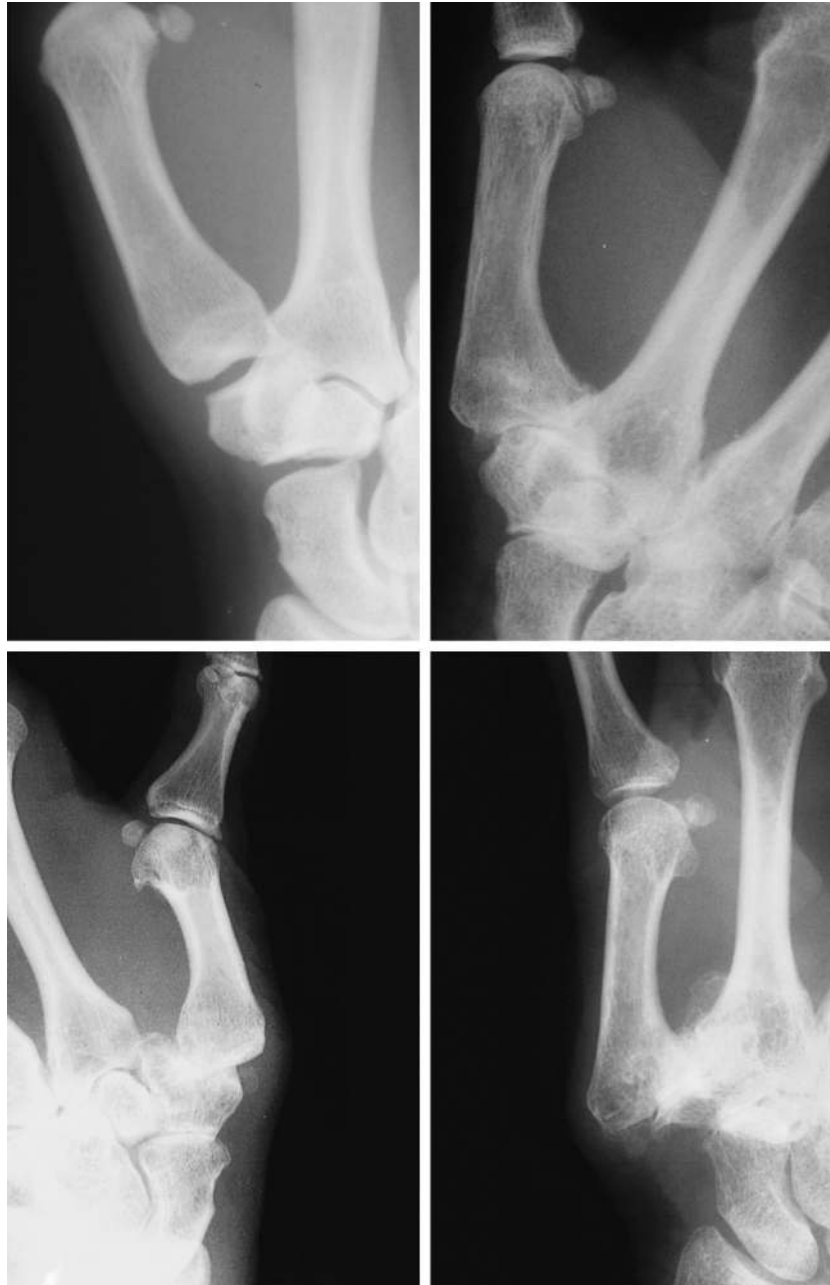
Radiographs demonstrating Eaton stages I (above, left), II (above, right), III (below, left), and IV (below, right).
